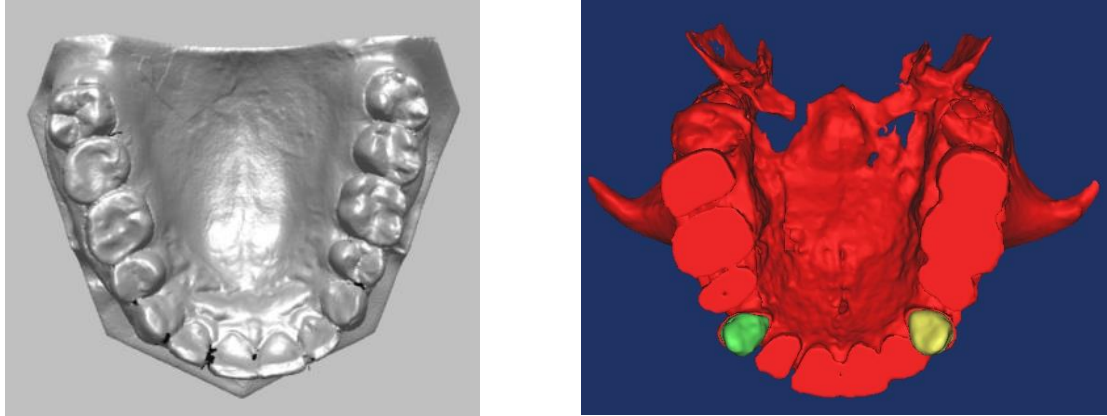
Dental cast and CBCT models.
